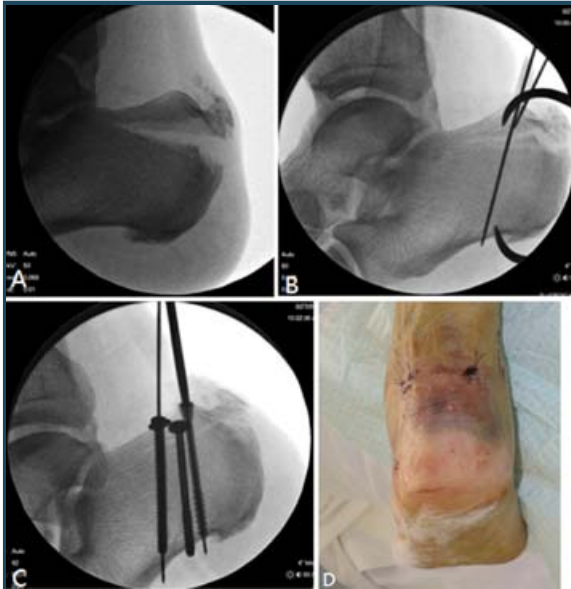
A: X-ray demonstrating displaced extra-articular fracture of the calcaneum. B,C: Closed reduction followed by insertion of three cannulated screws over the guide wires under fluoroscopy. E: Post-op photo showing three small surgical wounds
